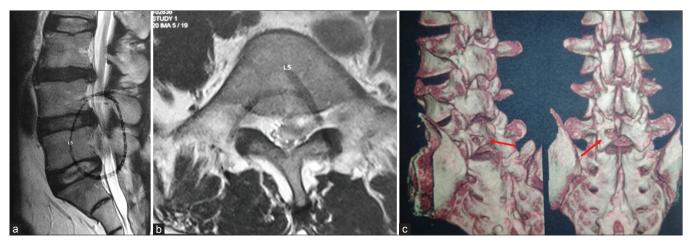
(a) Preoperative T2-weighted sagittal magnetic resonance imaging showing the inferiorly migrated L4 L5 disc. (b) Preoperative T2-weighted axial magnetic resonance imaging showing the migrated L4 L5 disc at left L5 pedicle level. (c) Postoperative three-dimensional reconstruction computed tomography scan showing the laminotomy hole in L5 on the left side
